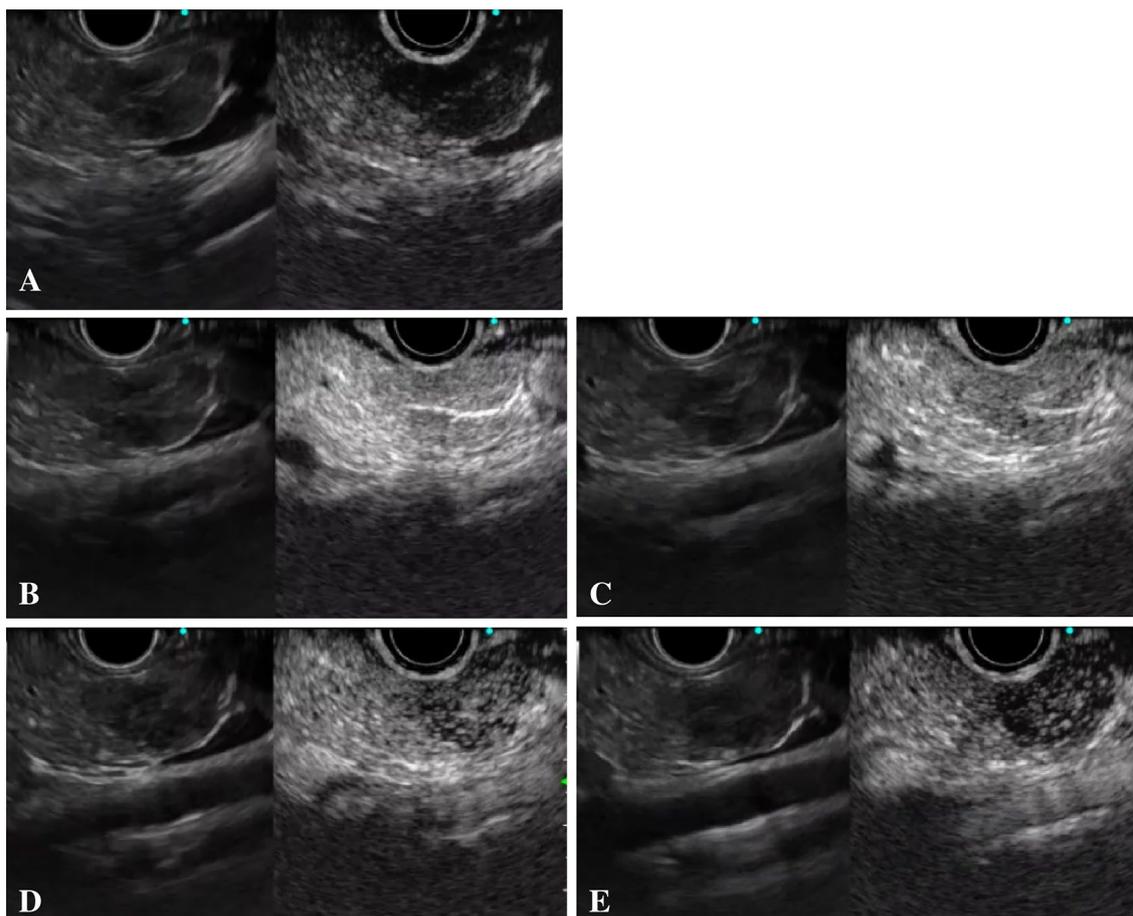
Contrast-enhanced endoscopic ultrasound after Sonazoid contrast injection. a Tumor before Sonazoid contrast injection. b The arterial phase, 15 s after contrast injection, shows hypoechoic enhancement of the tumor and a single vessel inside the tumor. c The perfusion
